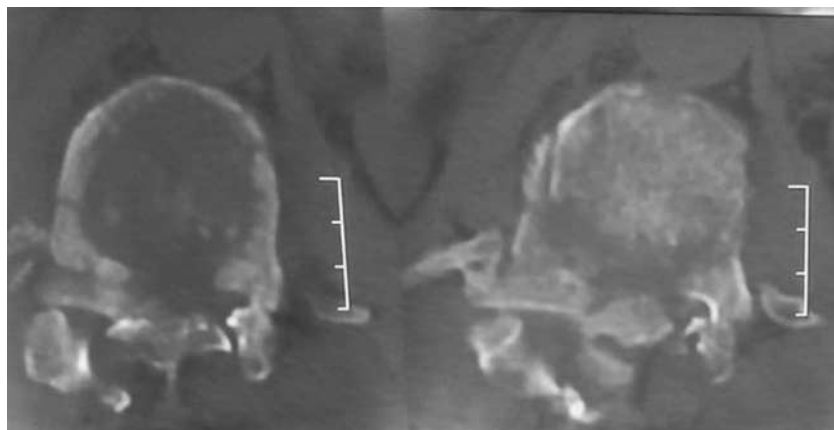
Preoperative computed tomographic scan (axial section) at the level of L1 vertebral body.
